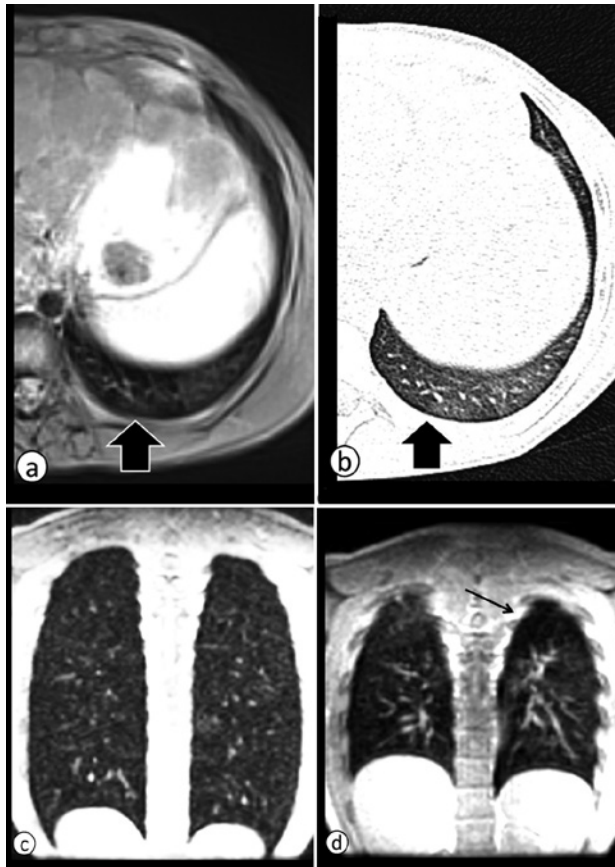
Trapped air and MRI. Trapped air assessment with MRI. (a) Free-breathing BLADE MRI, (b) CT at end expiration, performed the same day, (c) 3D SPGR MRI coronal reformat breath-hold at end-inspiration and (d) end-expiration. Note areas trapped air in the left lower lobe (thick arrow) and area of air trapping in the left upper lobe (thin arrow).
